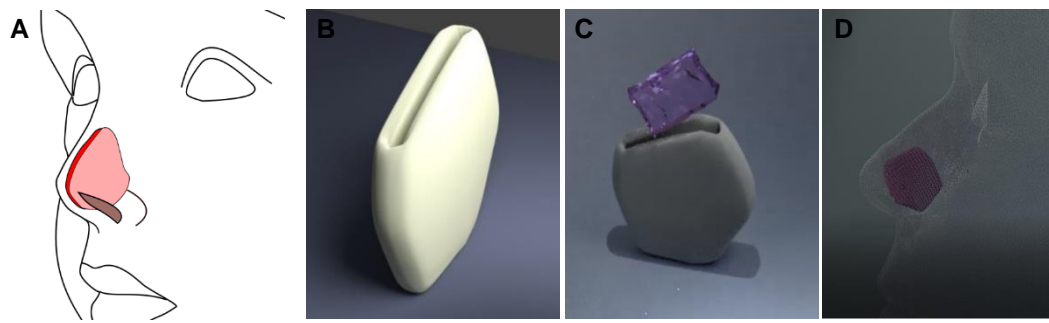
Pocket design concept. (A) The septal cartilage product dimensions can be estimated clinically or ideally by CT. (B) Pocket is then 3D printed using a biodegradable material. (C) The bioengineered cartilage core (Integra sheet) is inserted into the pocket following pre-differentiation in vitro. (D) The product is then inserted into the nose to reconstruct the missing septum.
